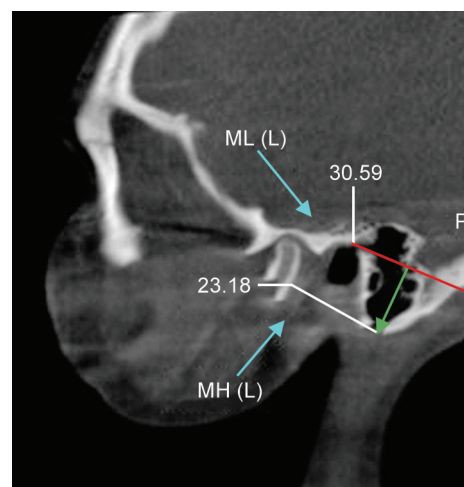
Cone-beam computed tomography (CBCT) image: Measurement of mastoid length (ML) and mastoid height (MH) of the left side of the mastoid
